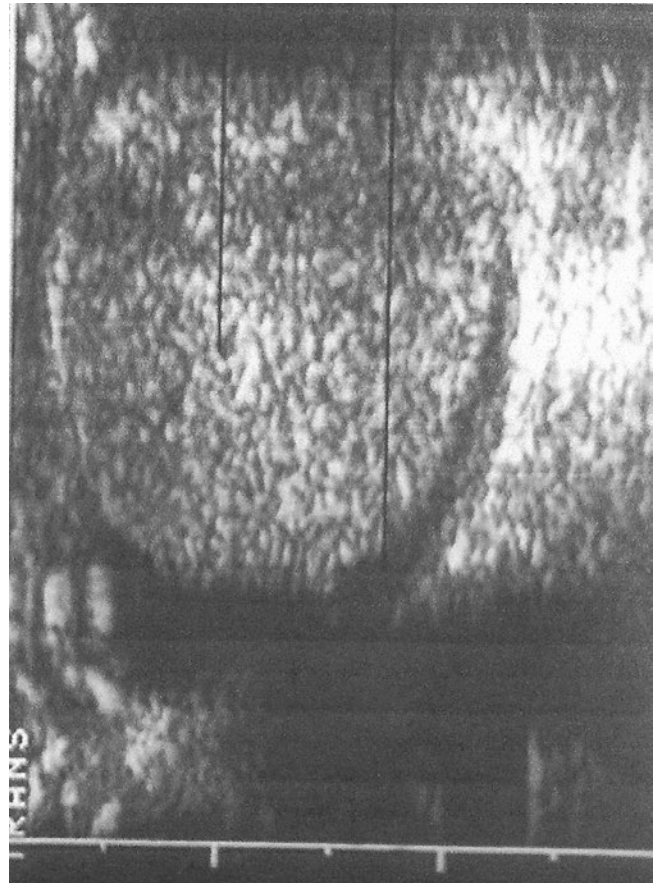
Ultrasound scan of Epididymo-orchitis with increased blood flow
